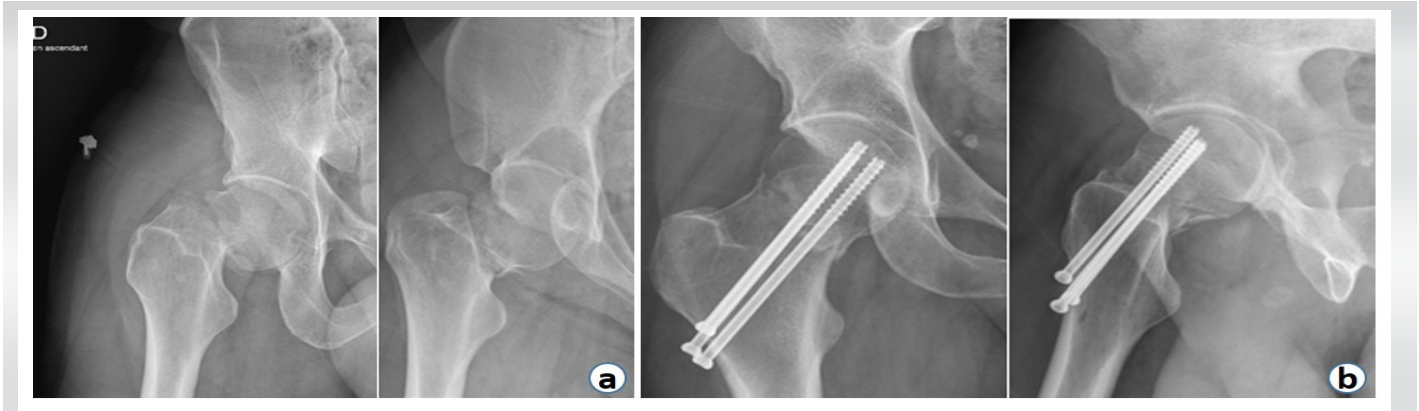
Pauwels' 3 femoral neck fracture (a) and treatment with screw fixation (face and profile) (b). (a) Frontal and profile post-traumatic X-rays. (b) Frontal and profile immediate post-operative X-rays.
